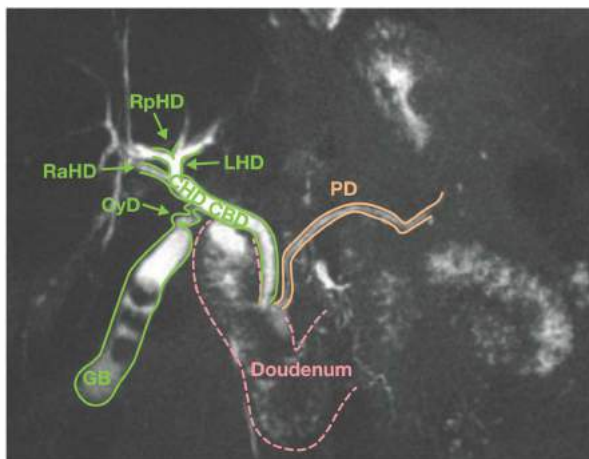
• Magnetic resonance imaging (MRI) showing biliary anatomy. The right and left systems drain into the CHD. This is joined by the cystic duct (*CyD*), which is notably tortuous as it drains into the biliary tree. This confluence marks the beginning of the common bile duct (*CBD*), which joins the pancreatic duct (*PD*) to drain into the second portion of the duodenum. The gallbladder (*GB*) can also be seen, with three large stones present. This patient's anatomy reveals a common variant (Type C), with the right posterior hepatic duct (*RpHD*) joining the left hepatic duct (*LHD*) while the right anterior hepatic duct (*RaHD*) drains directly into the CHD.
